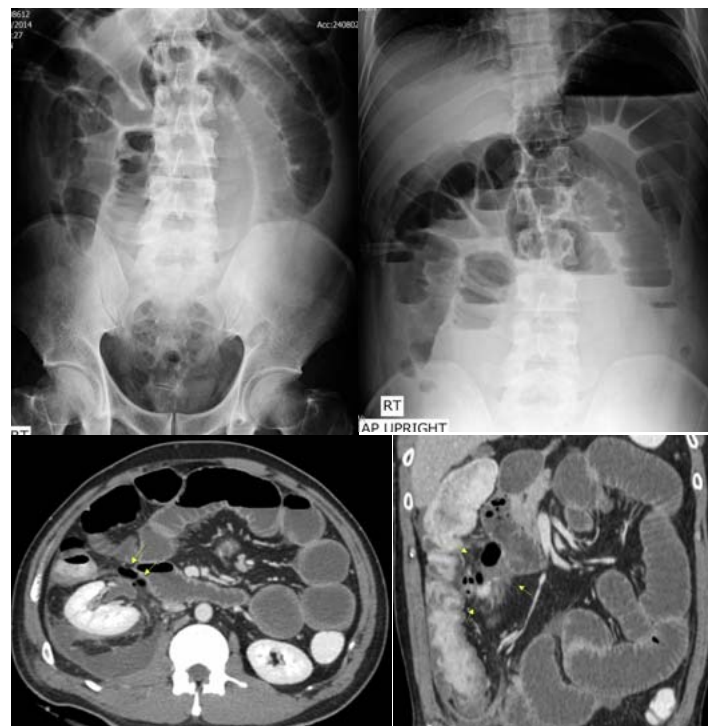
(Top row) Plain abdomen series of a 37-year-old man shows distal small bowel obstruction. (Bottom row) Axial and coronal CT reformations reveal no bowel obstruction. Hematoma and abnormal air are demonstrated at right anterior pararenal space from prior kidney procedure.
